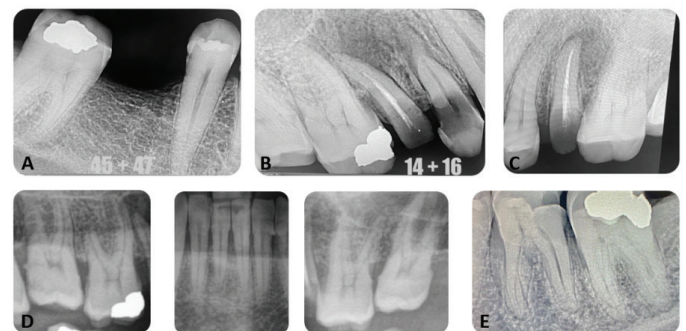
Series of periapical X-rays showing
